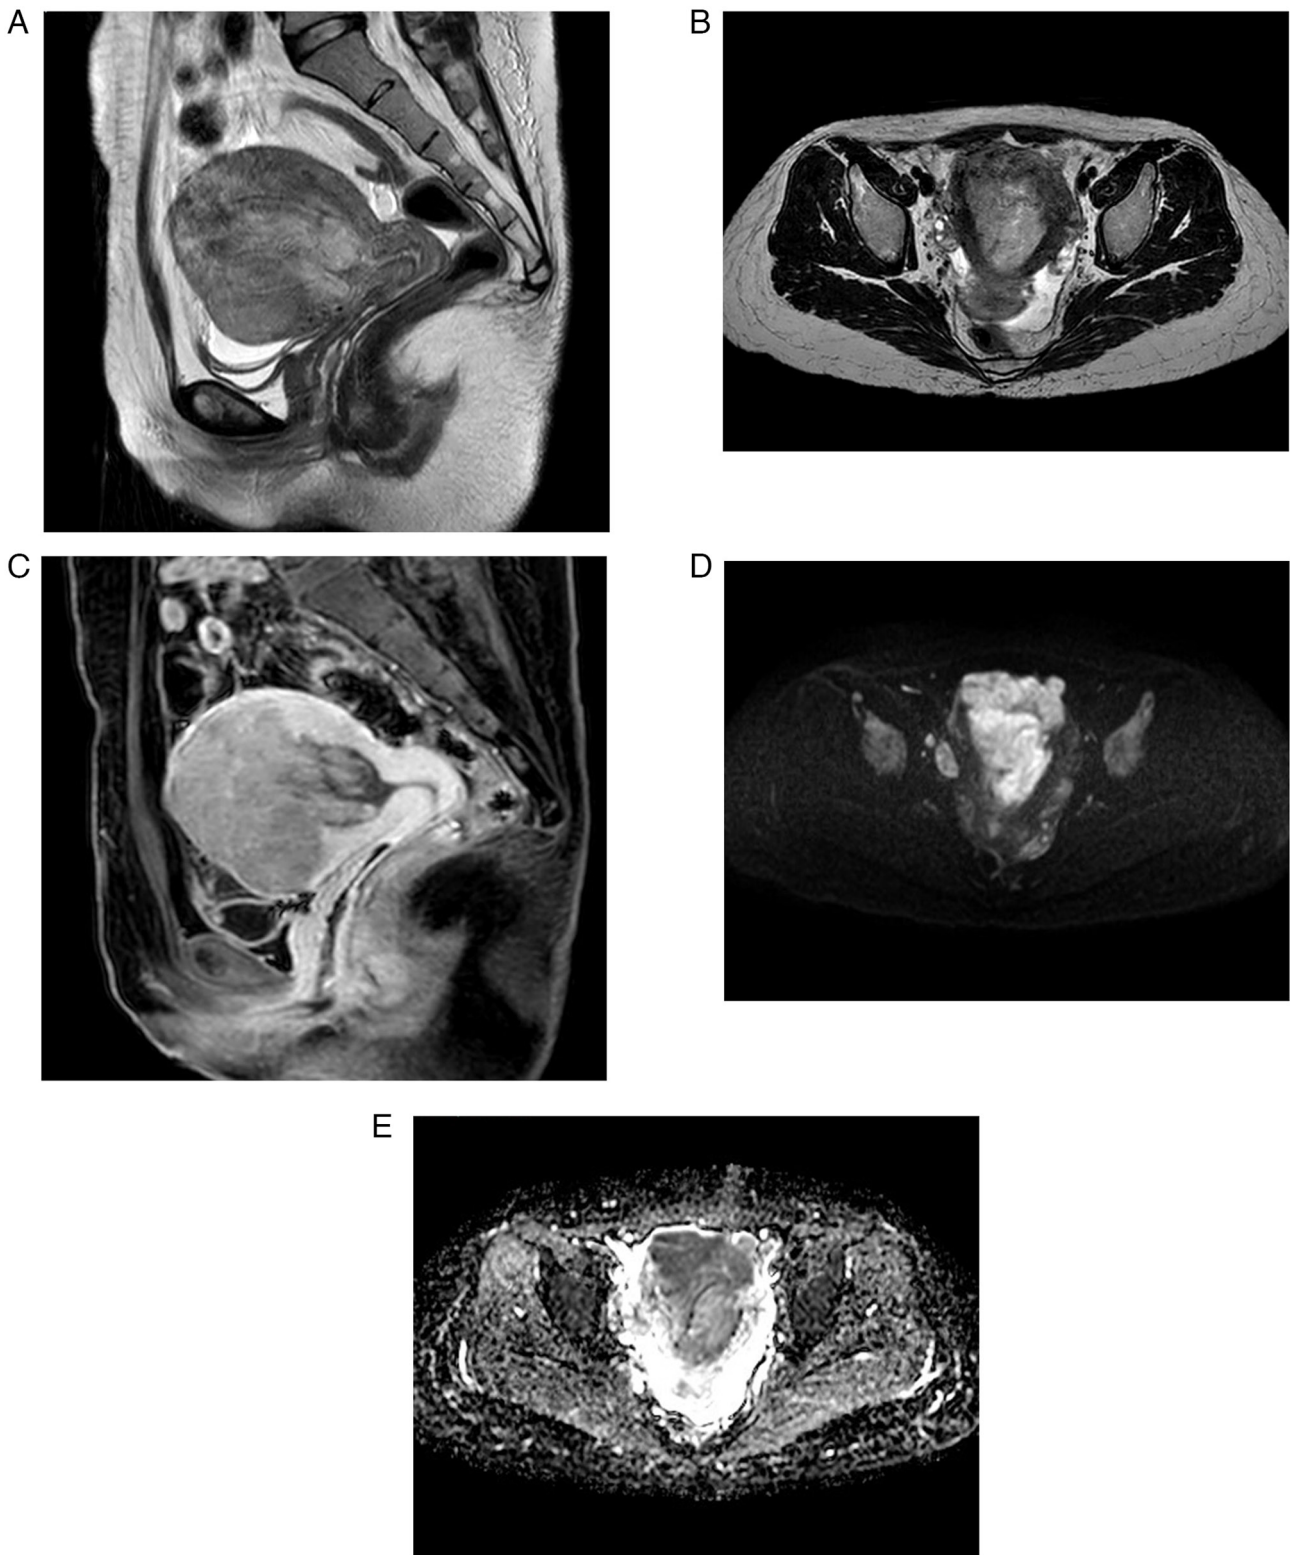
MRI findings. (A) Sagittal T2-weighted MRI showing an irregular uterine mass protruding from the myometrium into the endometrial cavity. (B) Axial T2-weighted MRI demonstrating the same uterine mass with heterogeneous SI. (C) Contrast-enhanced MRI showing mild enhancement of the lesion. (D) Diffusion-weighted imaging demonstrating high SI in the lesion. (E) Apparent diffusion coefficient map showing corresponding low SI, indicating diffusion restriction. SI, signal intensity.
